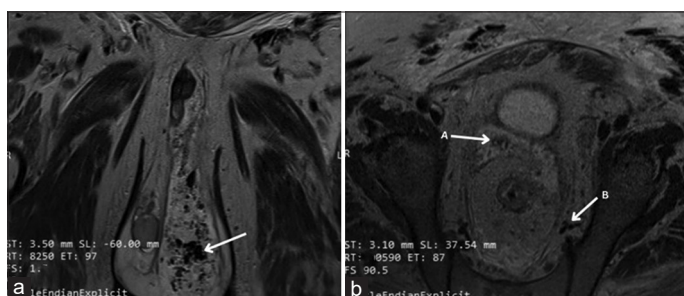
(a) Large collections with air pockets in left scrotal wall tracking into penile shaft and significant scrotal edema; (b) Semi-annular mass in low rectum and anal canal, with collection of air pockets posterior to urinary bladder wall measuring $7.2 \times 6.4 \times 1.5$ cm. Image shows axial oblique T2-weighted magnetic resonance imaging of the male Pelvic region with A and B specifying: (a) Semi-annular mass in low rectum and anal canal. (b) Collection of air pockets posterior to urinary bladder wall
